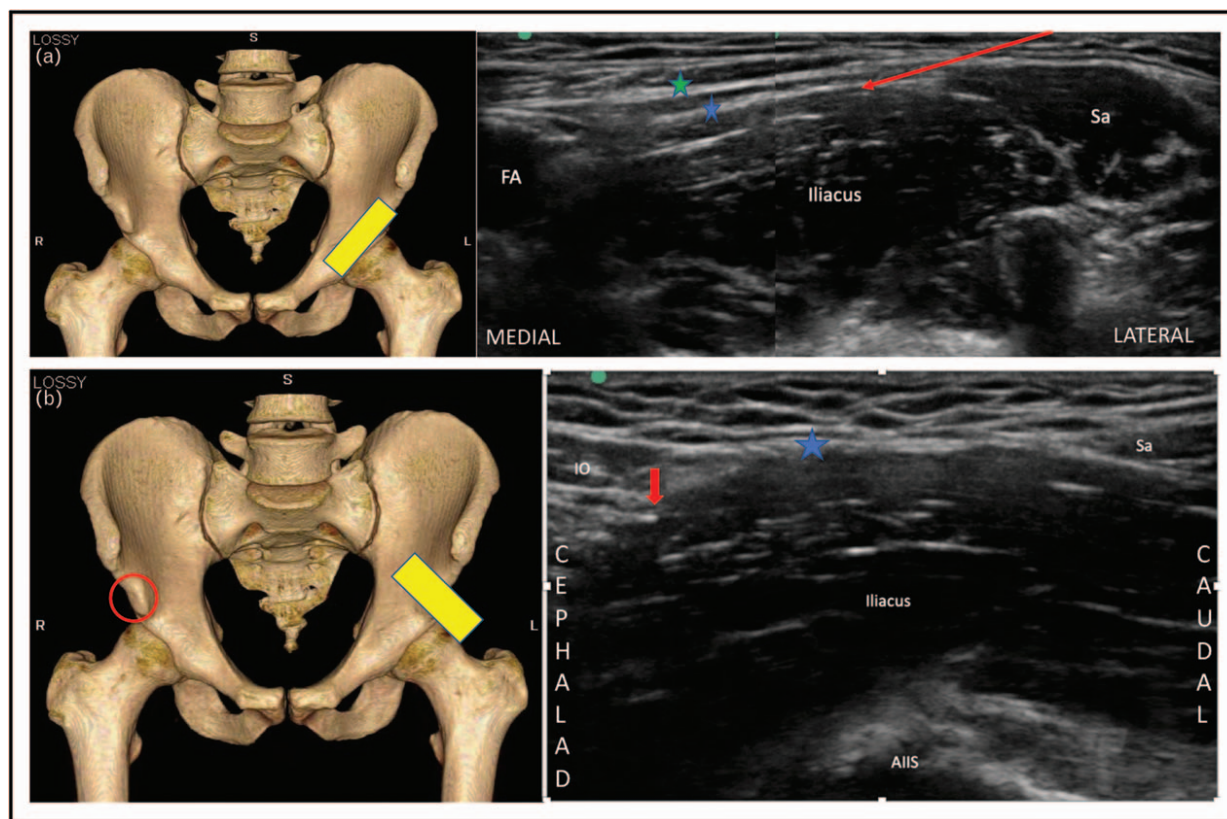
(a). Fascia iliaca classical approach: anatomic landmarks. Top left is the skeletal image showing the position of the ultrasound probe (yellow). Top right is the corresponding ultrasound image: FA: femoral artery, Iliacus: iliacus muscle, Sa: sartorius muscle, Green star: fascia lata, blue star: fascia iliaca, Red arrow: needle trajectory for the classical fascia iliaca block in plane from lateral to medial. (b). Suprainguinal fascia Iliaca approach : anatomic landmarks. Lower left is the skeletal image showing the position of the ultrasound probe (yellow). Red circle: anterior inferior iliac spine. Lower right is the corresponding ultrasound image. AIIS: anterior inferior iliac spine, IO: internal oblique muscle, Sa: sartorius muscle, Iliacus: iliacus muscle, Blue star: fascia iliaca, Bold arrow: target for the needle tip. Reprinted with permission from Philip Peng Educational Series.
